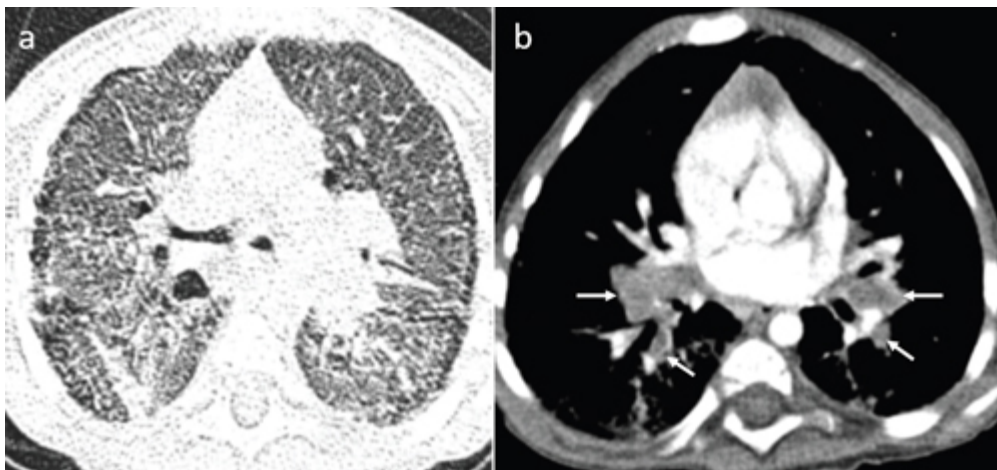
Thorax CT showed (a) diffuse ground-glass opacification, peripheral subpleural milimetric cysts on both lungs, and (b) lymphadenopathies (arrows) in the bilateral hilum.
